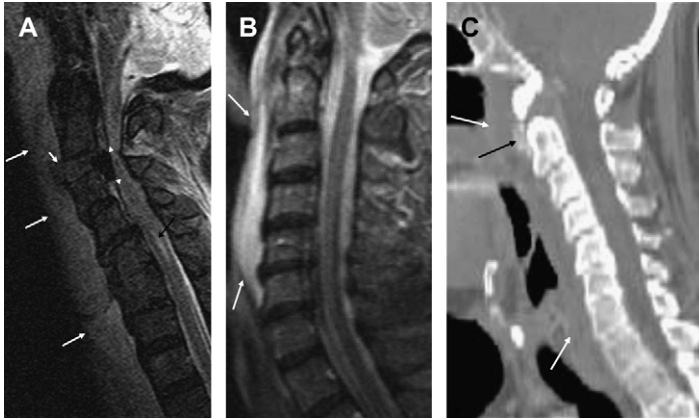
Prevertebral edema. (A) Acute ligamentous injury. Sagittal T2—severe spinal trauma resulting from flexion extension injury with extensive prevertebral edema (*long white arrows*), anterior ligamentous disruption (*small white arrow*), posterior ligamentous disruption and epidural hematoma (*small white arrowheads*), and diffuse cord contusions (*dark arrow*). CT was negative for fractures. (B, C) Longus colli calcific tendonitis—extensive prevertebral edema on sagittal T2 (A) (*arrows*) and prevertebral focal calcification (*dark arrow*) on reconstructed sagittal CT soft tissue neck image (B). Note prevertebral edema on CT (B) (*white arrows*).
